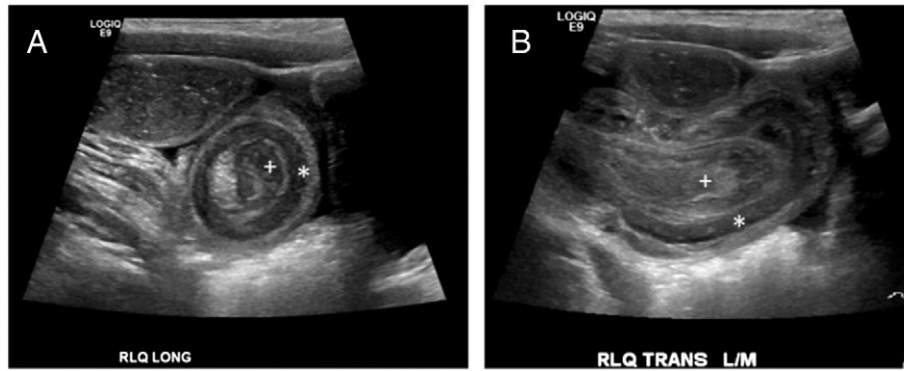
Abdominal ultrasound demonstrating intussusception with intussusciens (*) and intussusceptum (+) in long (A) and transverse (B) views.
